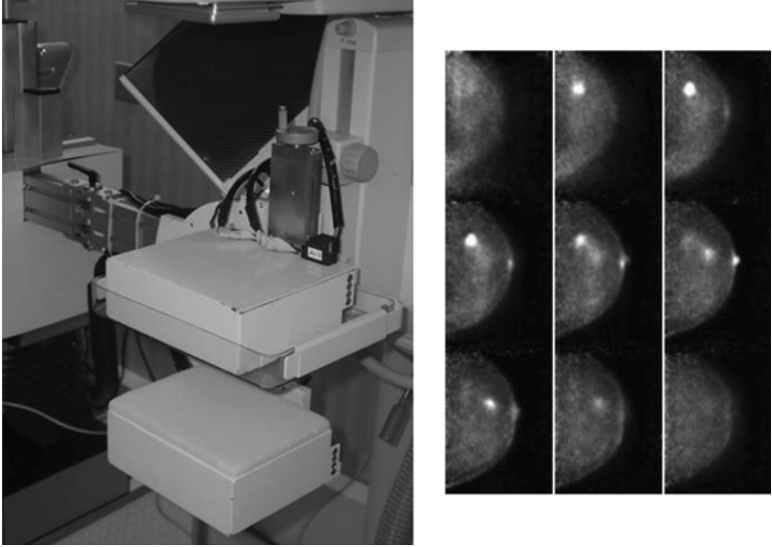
A positron emission mammography (PEM) device developed by Jefferson National Laboratory and being evaluated by Duke University Medical Center is shown on the left. The two detectors are placed on a mammography unit; the breast is positioned on the lower detector and the upper detector is lowered with the compression device for imaging. The tomographic images shown on the right reveal FDG accumulation in a large breast cancer.
